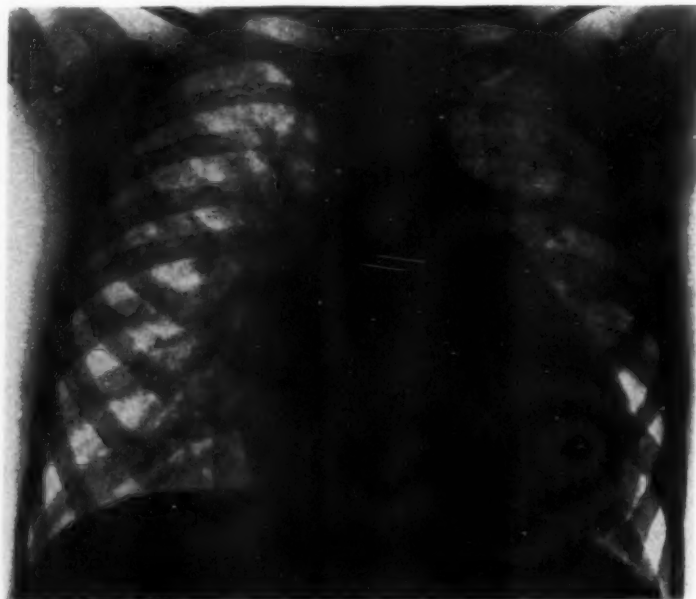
Roentgenogram of M. B. The heart is enlarged to the right and left with broadening of the waist. The pulmonary artery and its branches are prominent. The aortic arch is small.
